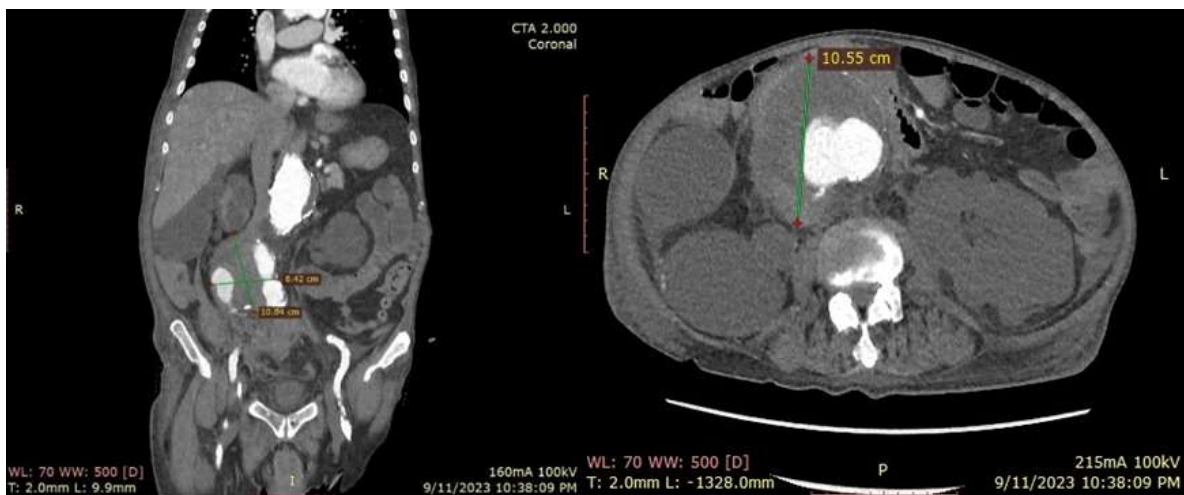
and Fig. 7. Computed tomography angiography (CTA) of the abdominal aorta showing just before the bifurcation of the common iliac artery, a larger saccular aneurysm with dimensions CC - 8.5cm, LL - 8.4cm and AP - 10.5cm, filled with a denser content and different zones of hemorrhage in organisation.
